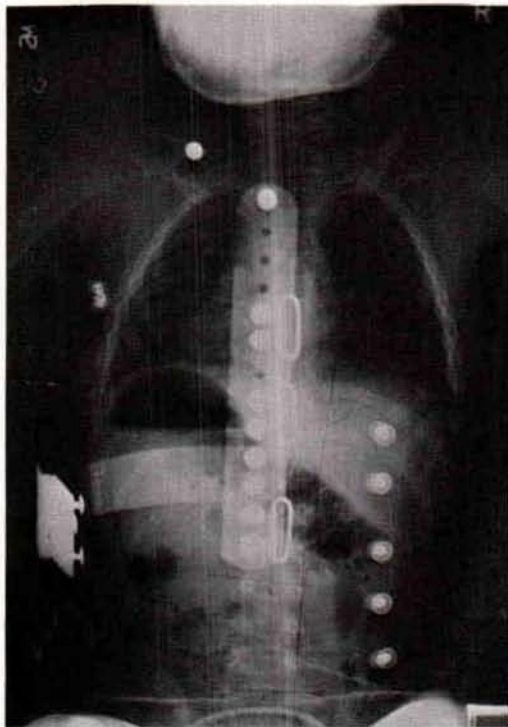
The A-P X-ray of the child shown in Figure 9 and his Sitting Support Orthosis.
